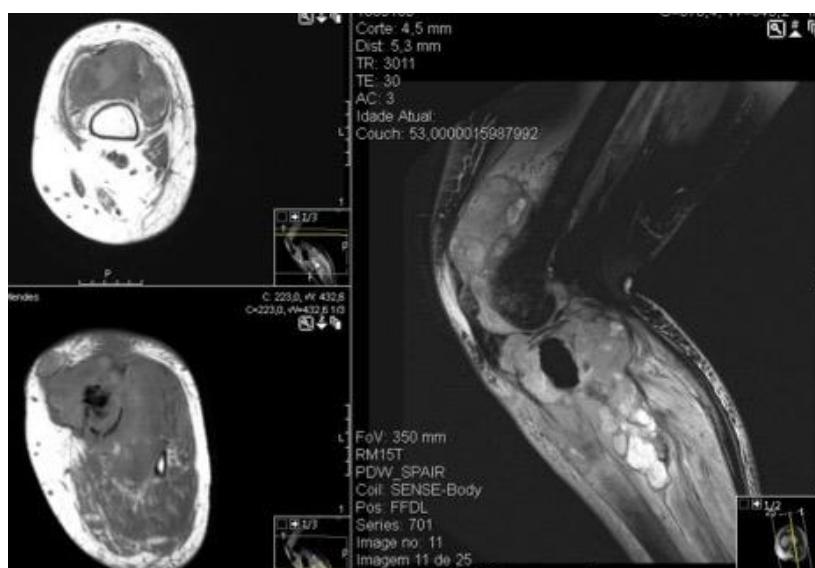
MRI showing a large soft tissue mass in the left proximal tibia invading the adjacent muscles, the knee articulation and the suprapatellar recess
